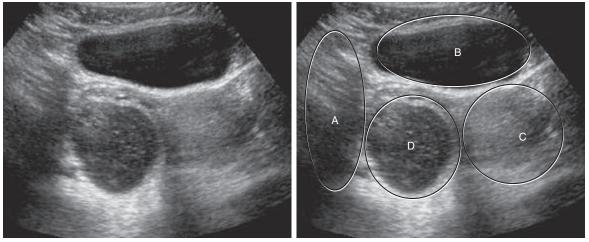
Transabdominal transverse sonogram.
